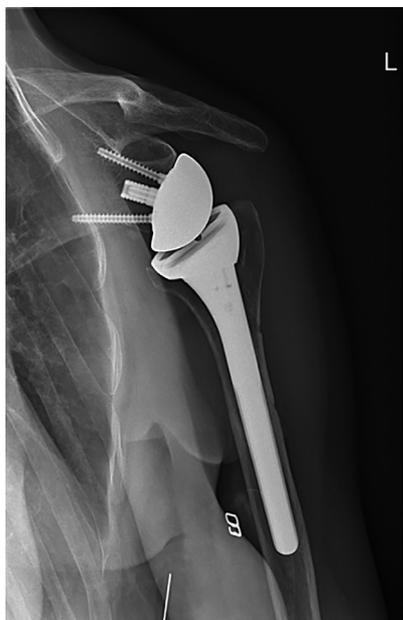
Radiographic control of ingrowth of the bone block. (A : axial view, B : AP view)
